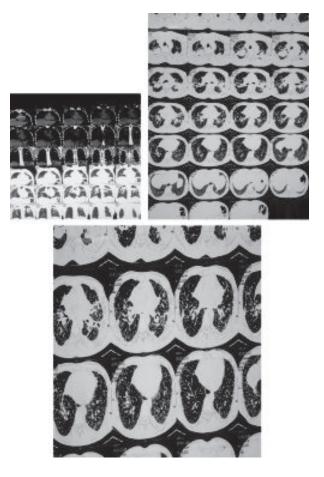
(a,b,c): HRCT of chest.
